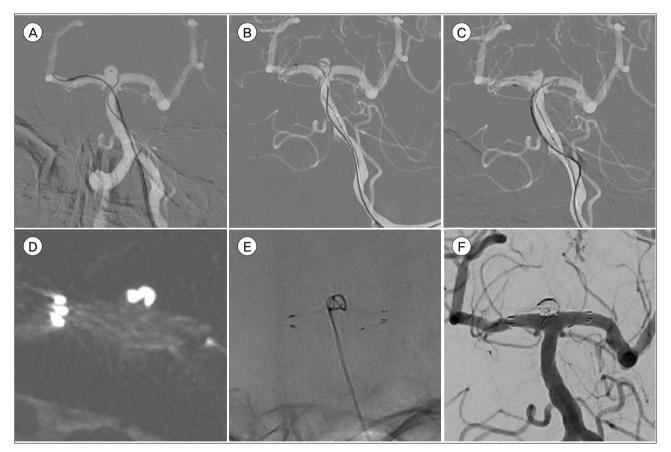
(A) For a BABIF aneurysm, a microcatheter was selected and a delivery microcatheter was navigated into the right PCA. Note the shape of the undertall- and overwide-neck aneurysm in the anteroposterior plane. (B) Anchoring the proximal portion of the Enterprise stent to the right PCA by microcatheter unsheathing and stent pushing. (C) As the stent is pushed, the steamed curved portion of the delivery microcatheter is moved toward the contralateral PCA, with final deployment by unsheathing. (D) The Vaso-CT image that confirmed the horizontal stenting. (E) Framing achieved with the stent. (F) Complete stent-assisted coil embolization. BABIF = basilar bifurcation; PCA = posterior cerebellar artery; CT = computed tomography.
